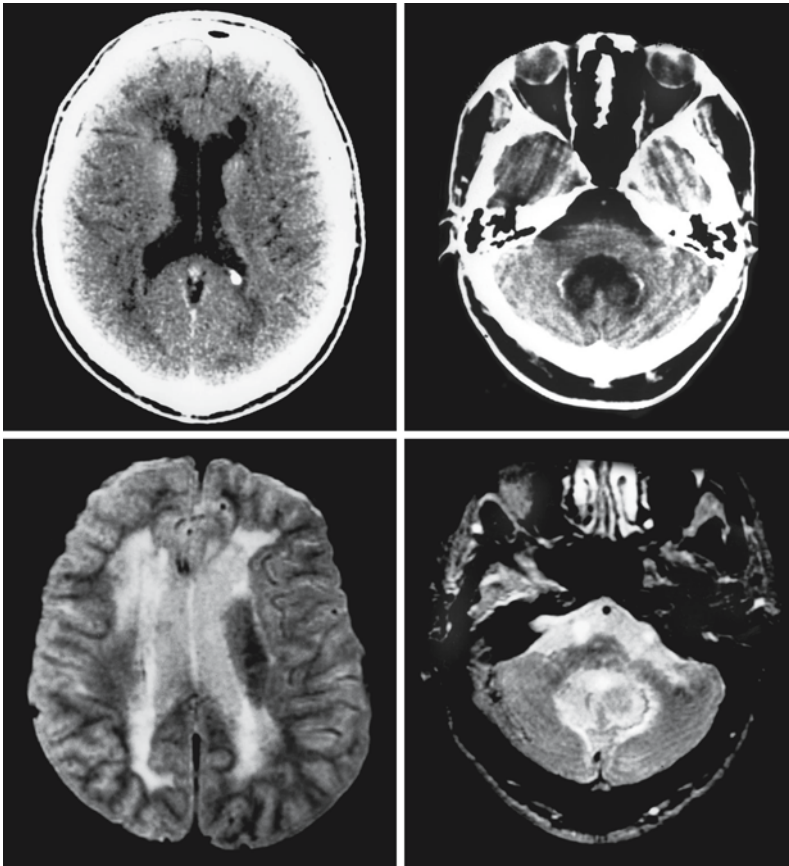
Male PLOSL patient, 29 years old. The CT scan demonstrates the calcium deposits in the caudate nucleus and dentate nucleus. The MRI reveals abnormalities in the periventricular and deep white matter, sparing the U fibers. The hilus of the dentate nucleus and deep cerebellar white matter is affected as well. From Malandrini et al. (1996), with permission
